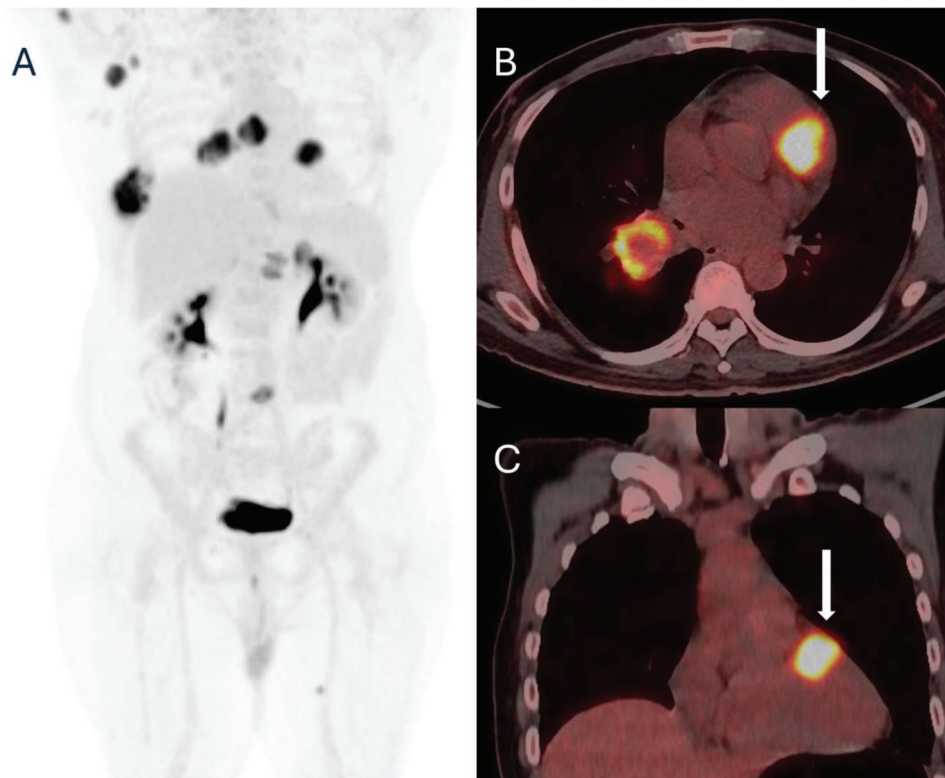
Patient 4 Panel A: Whole-body PET maximum intensity projection (MIP) image demonstrating FDG-avid lymph nodal, skeletal, adrenal gland, and cardiac metastases. Panels B and C: Fused PET/CT axial and coronal images highlighting myocardial metastases (white arrow).
